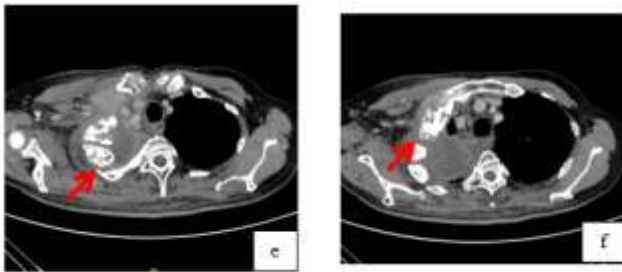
e) and f) Mediastinal view on axial section CT scan
